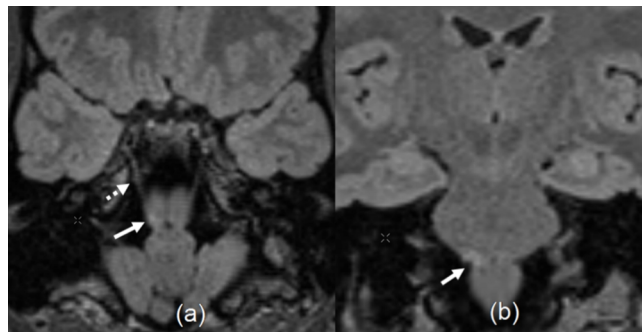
Clinically isolated syndrome of brainstem origin. A young patient presenting with diplopia, clinically attributed to right 6th nerve palsy. 3D FLAIR reconstructions in modified axial (a) and coronal (b) planes show signal abnormality (white arrow) at the pontomedullary junction, at the attachment of abducens nerve (dotted arrow in a)
